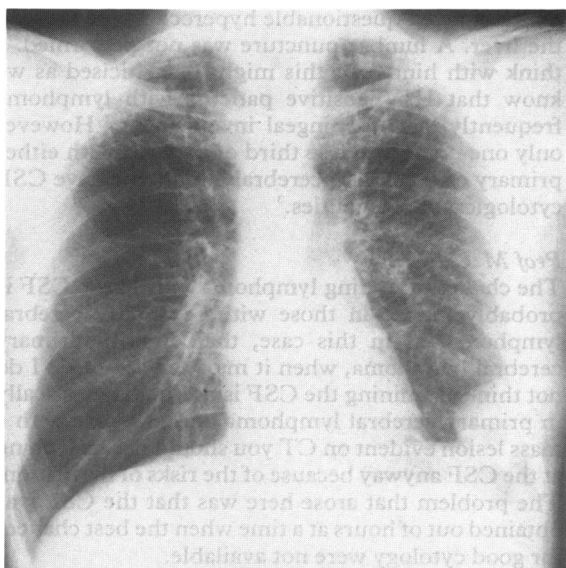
Chest radiograph showing a left pleural mass (arrows).
